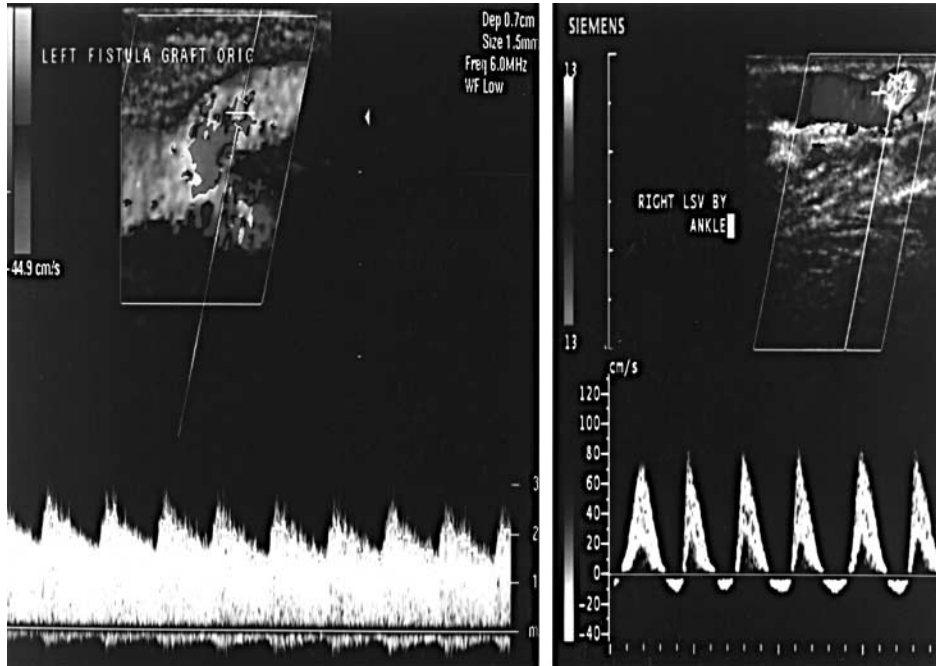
Colour doppler flow curves of tricuspid regurgitation (right) and a hypothetical arteriovenous fistula (left). The right hand display shows a biphasic pulsatile jet form at the ankle of 80 cm/s towards the transducer (conventional orientation, with head of patient to left of picture).
